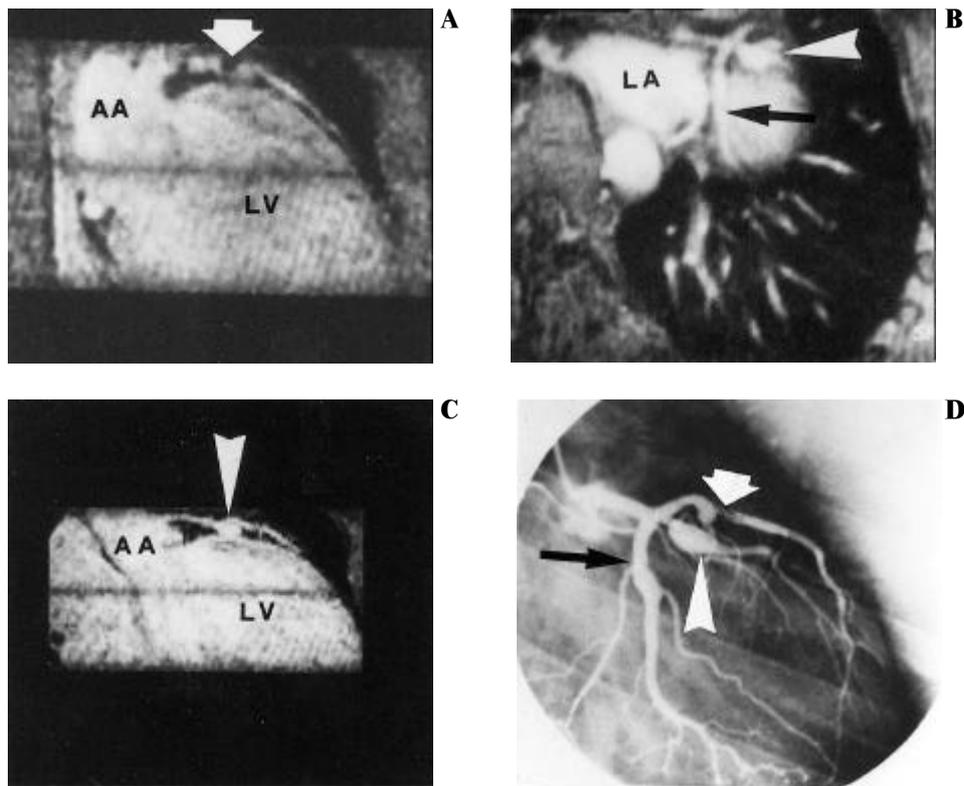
A, B, and C: navigator-echo magnetic resonance coronary angiography. D: conventional coronary angiography. A: reformatted oblique sagittal image, signal attenuation (white arrow) due to coronary stenosis of the proximal left anterior descending coronary artery. B: reformatted paraaxial image, moderate dilation of the left circumflex coronary artery (black arrow) and aneurysm of the ramus medianus (white arrowhead). C: reformatted oblique sagittal image, different view of the aneurysm of the ramus medianus (white arrowhead). D: conventional coronary angiography of the left coronary artery confirming the same findings (labeled as in magnetic resonance images). AA = ascending aorta; LA = left atrium; LV = left ventricle.
